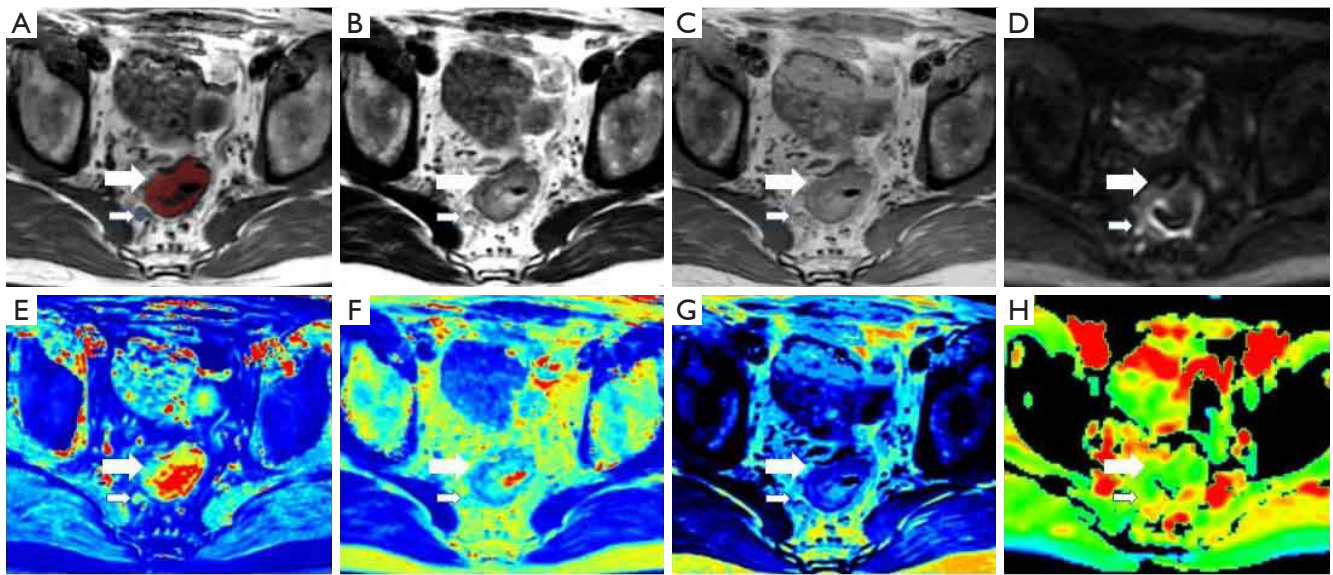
A 48-year-old man with moderate differentiation RC [T3N2, mesorectal fascia (-), extramural venous invasion (+)]. (A-C) synthetic T1-, T2-, and PD-weighted images, respectively; (D) axial DWI ($b=800 \text{ s/mm}^2$); (E-G) T1, T2, and PD maps derived from SyMRI indicating the mean T1, T2, and PD values, which were drawn along the contour of the tumor on the slice with the largest tumor diameter were 1,284 ms, 80 ms, and 72 pu, respectively. (H) ADC map indicates that the mean ADC value was $1,595 \times 10^{-6} \text{ mm}^2/\text{s}$. The small arrow points to the metastatic lymph node; the large arrow points to the tumor. RC, rectal cancer; PD, proton density; DWI, diffusion-weighted imaging; SyMRI, synthetic magnetic resonance imaging; ADC, apparent diffusion coefficient.
